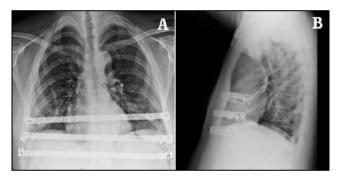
X-ray examination of chest wall after operation.
